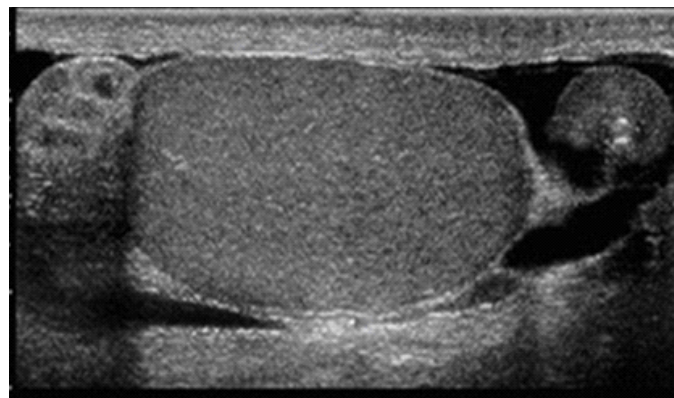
Ultrasound (Post-treatments, this is not definitive for varicocele)
